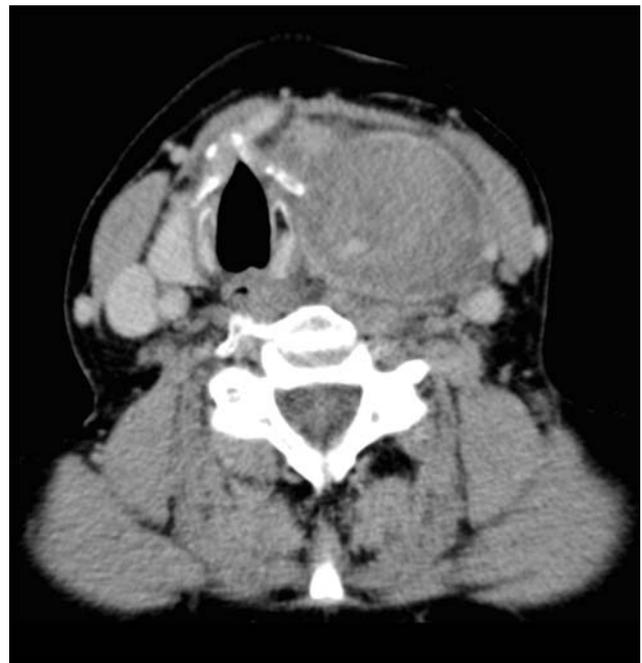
CT scan (transverse view) of the anterior neck showing left thyroid hematoma with contrast extravasation indicating active bleeding.
